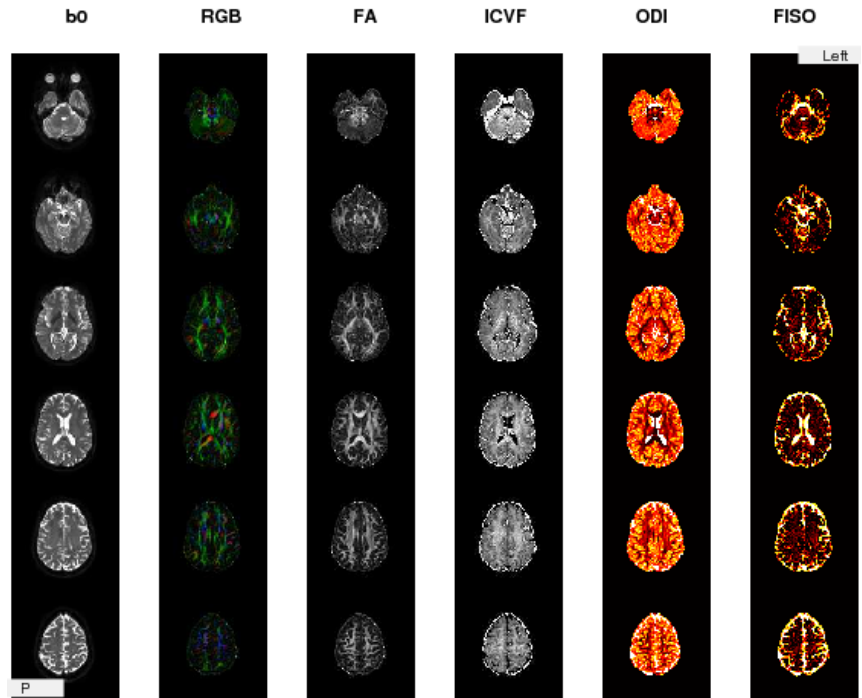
Examples of preliminary MRI analysis in a control subject.
